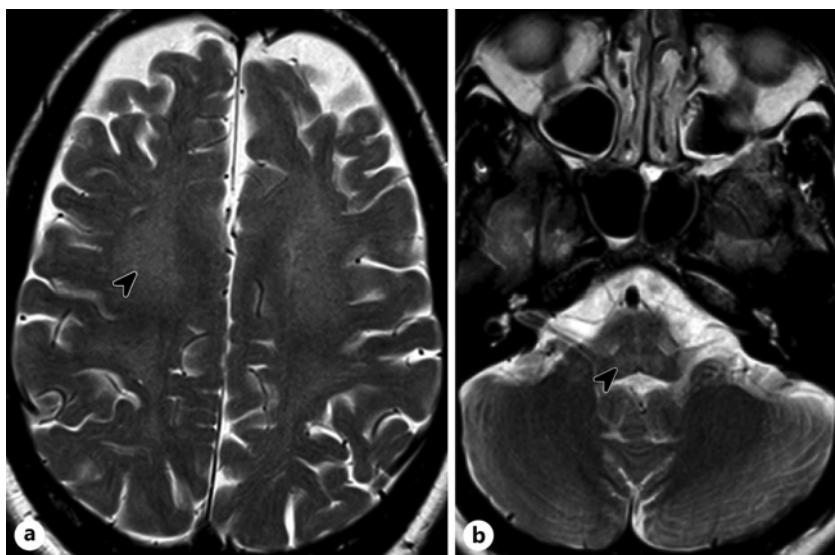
Axial T2w images of brain magnetic resonance imaging (MRI): frontal lobe cortical atrophy and diffuse hyperintense lesions in centrum semiovale and periventricular areas (a), as well as in pons without signs of cerebellar atrophy (b).
